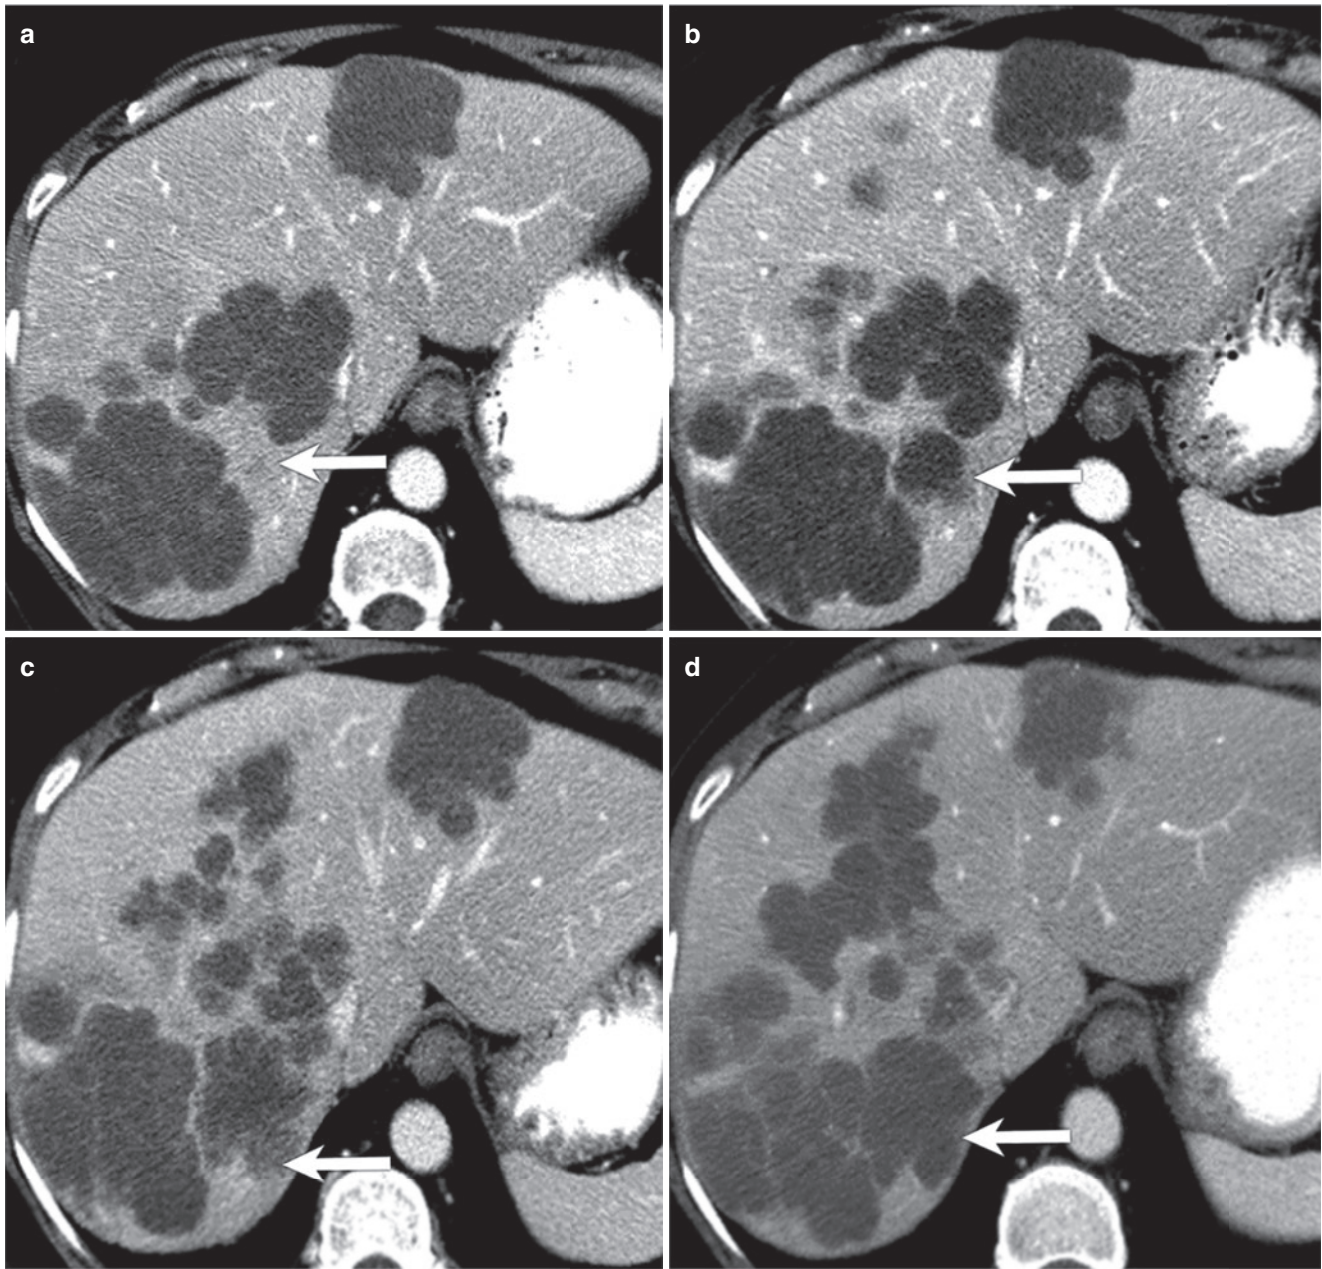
Value of delayed images to confirm recurrence. Baseline CT Portal phase (a–c), delayed phase (d–f) at baseline (a, d), after 6 cycles of FOLFOX/bevacizumab (b, e) and follow up after treatment interruption (c, f). Immediate posttreatment images (b, e) show optimal
